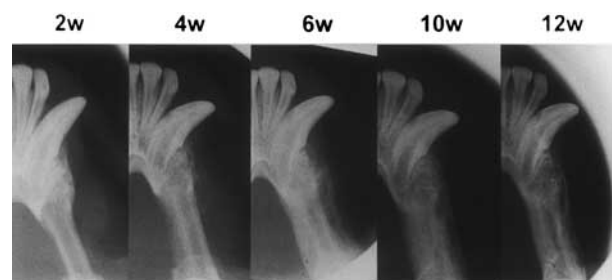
Time course of bone formation using rhBMP-2. Radiographs taken at 2, 4, 6, 10 and 12 weeks after implantation of rhBMP-2. Initial radiopacity at 4 weeks postoperatively, which increased by 10 weeks. The defects were reconstituted with new bone at 12 weeks.
